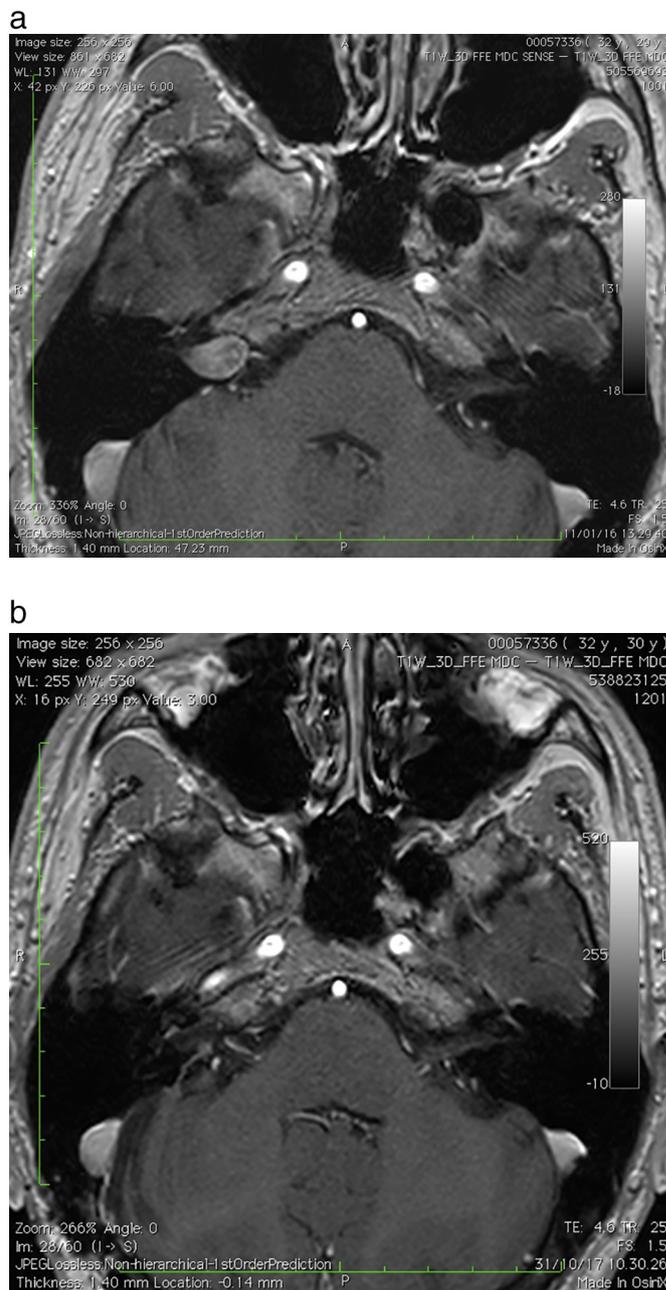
a: Preoperative axial MRI showing a left intra- and extra-canalicular tumor with contrast enhancement.
